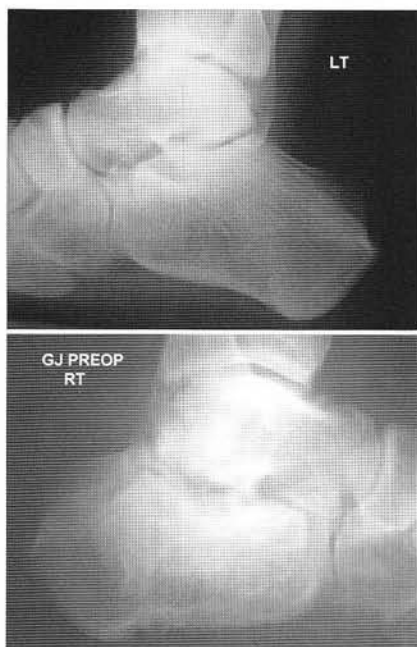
Lateral x-ray, right foot (right side) reveals radiolucency of subtalar joint and subchondral sclerosis consistent with nonunion of subtalar joint. Compare to normal left foot.
